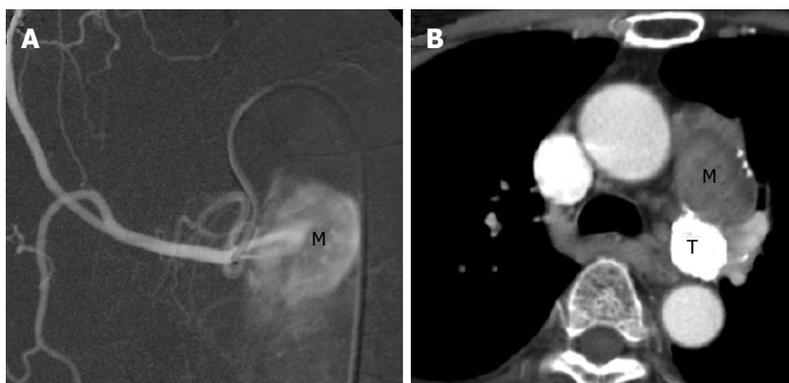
First session of transarterial embolization for mediastinal tumor. A: An angiogram of the right superior bronchial arterial branch showed a metastatic hepatocellular carcinoma (M) in the left hilum supplying by the first branch of right superior bronchial artery. Embolization was performed by lipiodol only; B: Chest computer tomography (CT) scan: Lipiodol retention in posterior portion of the mass (T) over aortopulmonary window region and decreased in size, but the anterior portion of the mass (M) over aortopulmonary window region increased in size as compared with previous CT.
